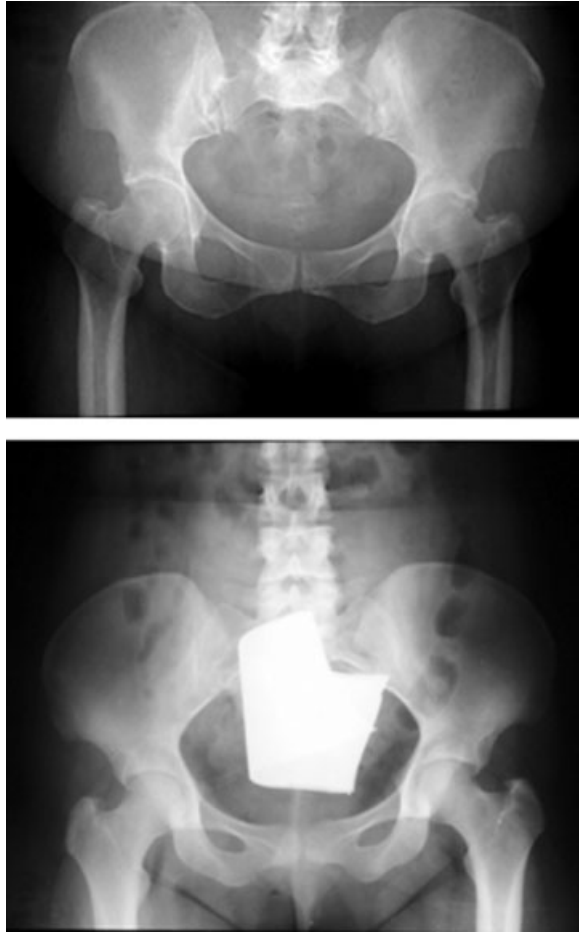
Radiographs of pelvises of two LS patients. Note the lateral flaring of the iliac blade relative to the plane of the acetabulum and the marked oval shaped pelvic inlet.
